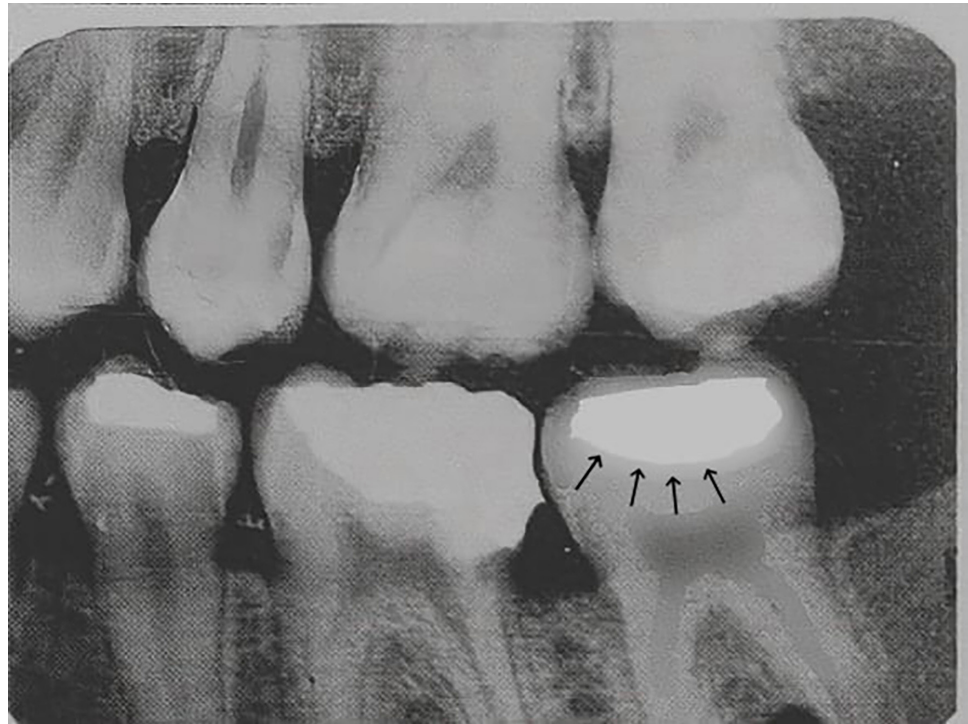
Post op bitewing. Arrows indicating Class I restoration on tooth #37
